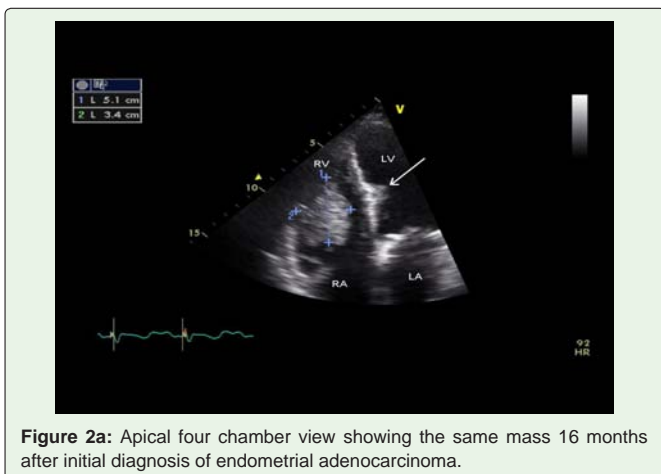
Apical four chamber view showing the same mass 16 months after initial diagnosis of endometrial adenocarcinoma.
